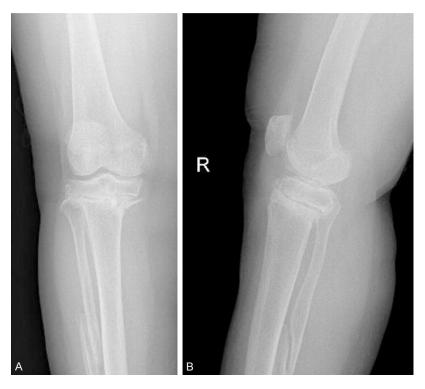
A. Preop AP X-ray demonstrate non-union at the osteotomy site. B. Preop lateral X-ray demonstrate non-union at the osteotomy site.
